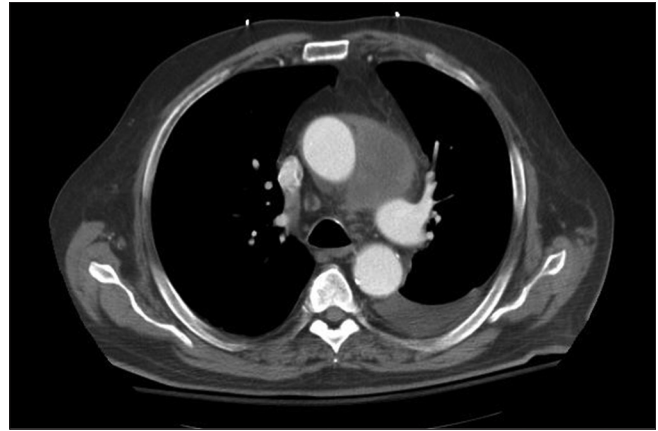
Axial computed tomography of the ascending aorta showing extensive intramural hematoma and left pleural effusion
